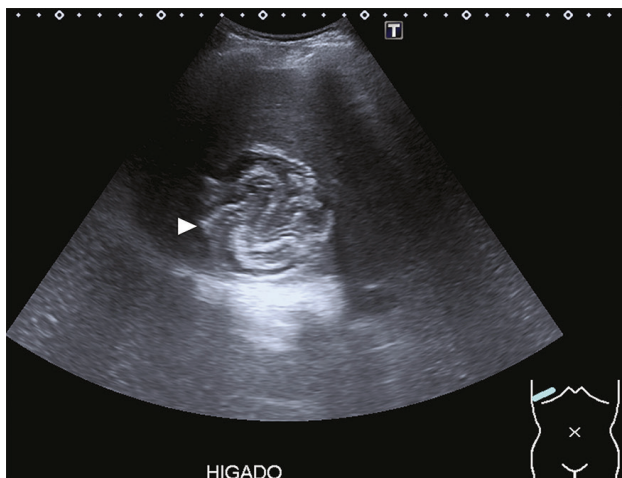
Abdominal ultrasound in a 48-year-old patient with right upper quadrant pain shows, in the liver parenchyma, a heterogeneous lesion with echogenic linear structures inside (arrowhead) and posterior acoustic enhancement. Gharbi type II-CE3.
